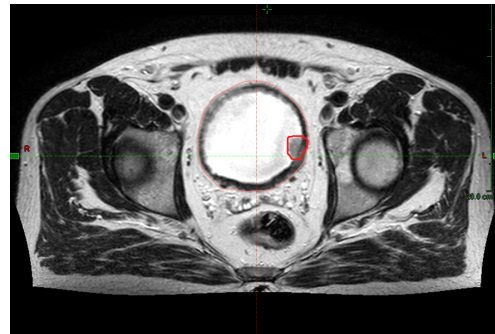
Transverse magnetic resonance image of a male patient with invasive bladder tumor marked red.*
